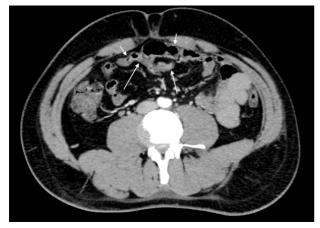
Meckel's diverticulum seen at the umbilical level on CT angiography
